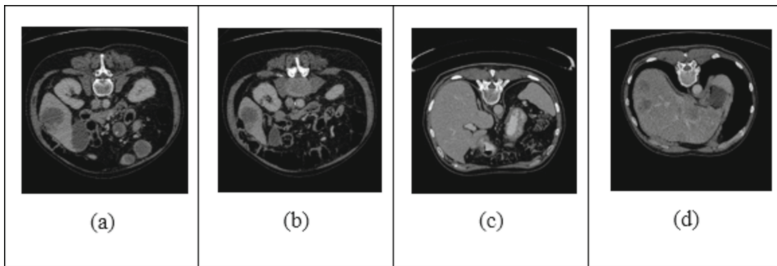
Sample CT images containing liver tumours from the datasets.
